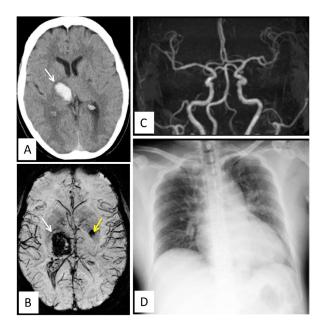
Clinical imaging for stroke signs upon initial presentation. (A) Head plane computed tomography image reveals a right thalamic hemorrhage (white arrowhead). (B) Susceptibility-weighted magnetic resonance image shows cerebral microbleeds (yellow arrowhead) in the left basal ganglia but no blood vessel malformations (white arrowhead). (C) Magnetic resonance angiography image reveals no aneurysms or blood vessel malformations. (D) Chest radiography shows no apparent heart expansion or pulmonary edema.
